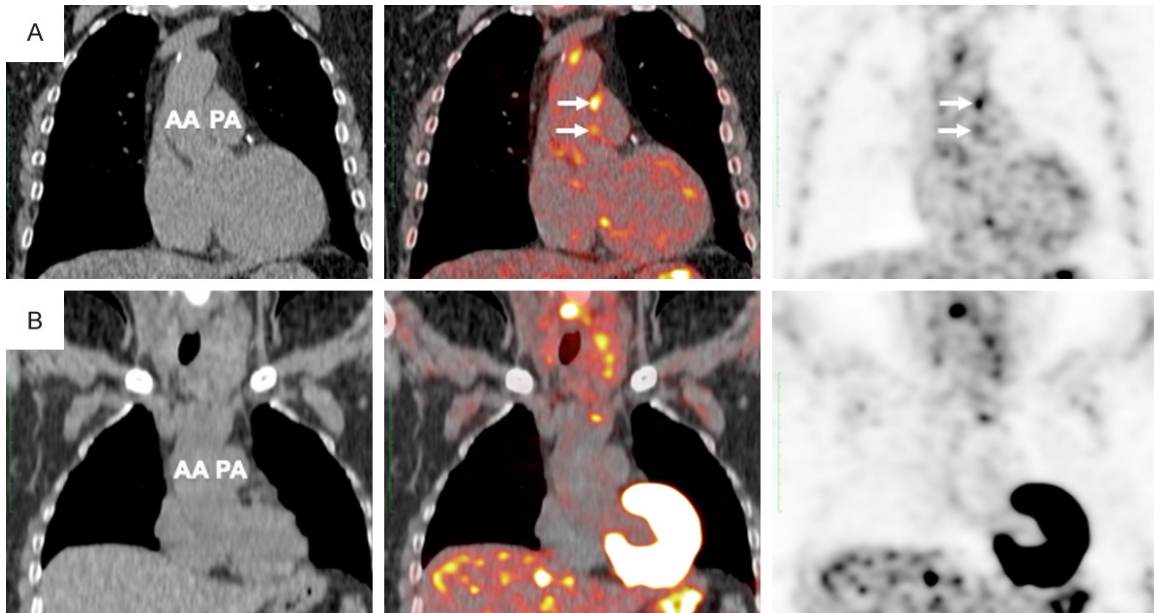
CT, fused PET/CT, and PET images of the main pulmonary artery (PA) and the ascending aorta (AA) in (A) a COPD patient and (B) a healthy control. In the COPD patient, there was focal FDG uptake (arrowheads) in the wall of PA. In contrast, no FDG uptake was visualized within the PA of the healthy control (the series of hot spots above the aorticopulmonary trunk is likely incidental from cervical lymph nodes).
